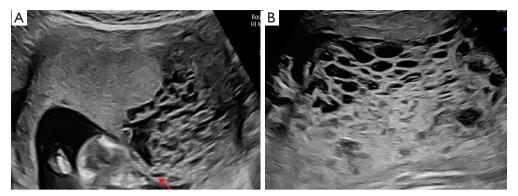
Case 2. (A) Ultrasound image at 20 weeks of pregnancy with PMD. The red arrow indicates the entrance of the umbilical cord into the placenta. The demarcation between the affected area and normal placental tissue is distinct, with the affected region situated at the entrance of the umbilical cord into the placenta. (B) Ultrasound image at 22 weeks of pregnancy with PMD. The placenta exhibits thickening, and the extent of cystic, echo-free structures gradually decreases. The affected area partially encompasses the entrance of the umbilical cord into the placenta. PMD, placental mesenchymal dysplasia.
